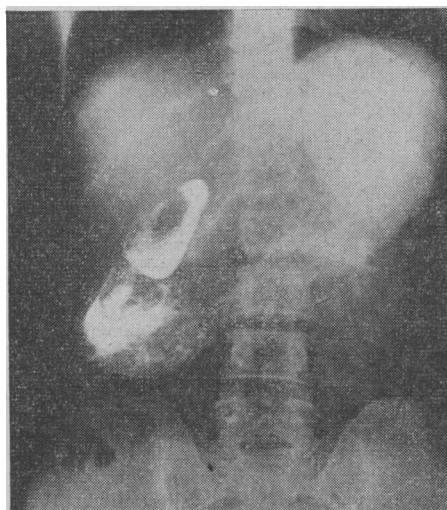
X-ray of the abdomen taken after barium showing the filling defects in the stomach and in the second part of the duodenum.
